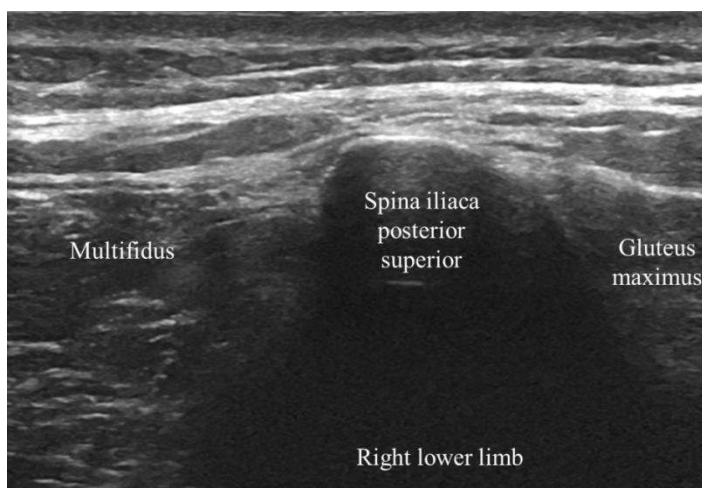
Ultrasound image of right lower limb is shown in resting position. Medial to the posterior superior iliac spine is the sacral part of multifidus and lateral lies gluteus maximus. These anatomical landmarks allow access to the LDL by locating the posterior superior iliac spine and then following the ligaments orientation in a medial-caudal direction. The ultrasound imaging was performed with a 5 – 15 MHz linear probe using an LOGIQ S7 Expert (General electric, Wauwatosa, USA)
